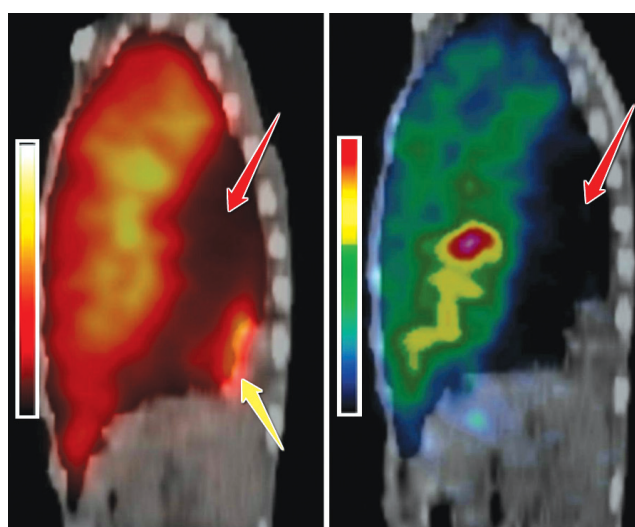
Perfusion (99mTc-MAA) and ventilation (Technegas) sagittal SPECT-CT scans. Matching perfusion-ventilation defect in the lower left lobe is visible (A, B, red arrows). Perfusion in the lower left lobe is preserved only in the parenchymal consolidation area in the posterior lateral segment (A, yellow arrow)
